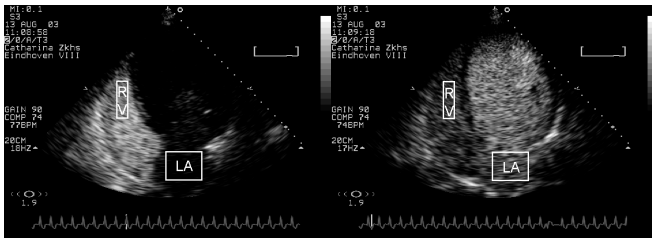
Transthoracic echocardiographic four-chamber view. Two ROIs are placed on the RV and LA for the IDC measurements. The opacification of the right and left side (after the transpulmonary passage of the UCA bolus) of the heart can be noticed on the left and right image, respectively.
